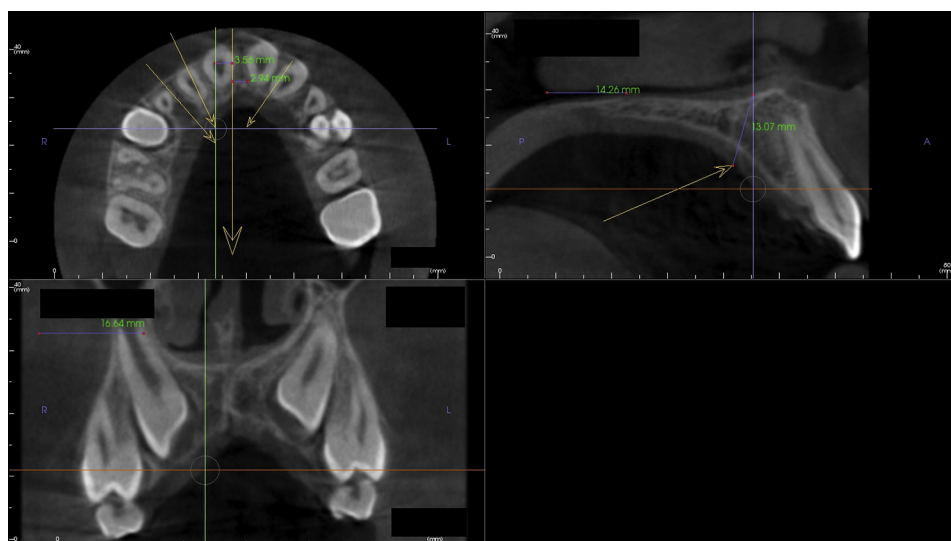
CBCT scan of the upper jaw and reference points to select the miniscrew insertion direction.
